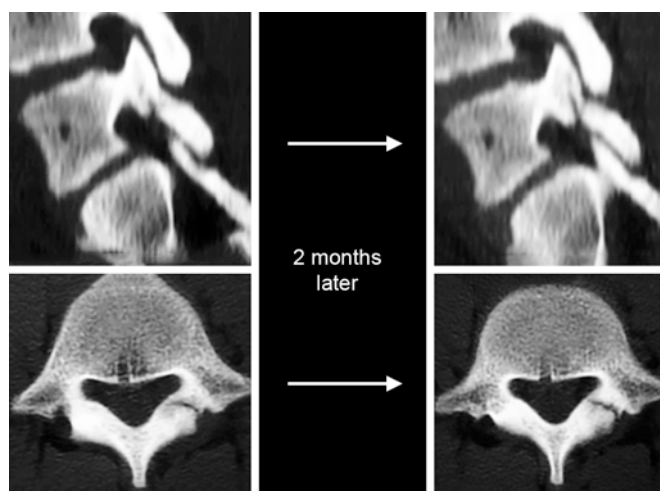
Computed tomography scans of 12-year-old girl who did not comply with conservative treatment. The fracture line at the caudal-ventral aspect of the pars extending to the cranial-dorsal side 2 months after diagnosis.
